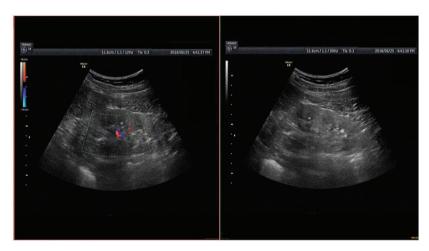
Abnormal echo of the bilateral kidneys (consistent with sonographic changes in chronic kidney disease) indicates multiple calculi or calcifications in the kidneys.
